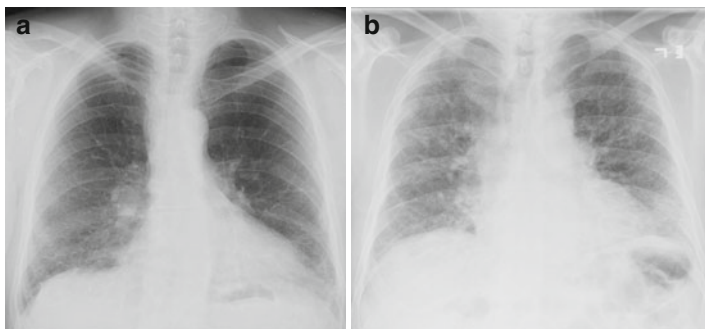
Chest X-rays showing (a), early and (b), advanced interstitial changes
